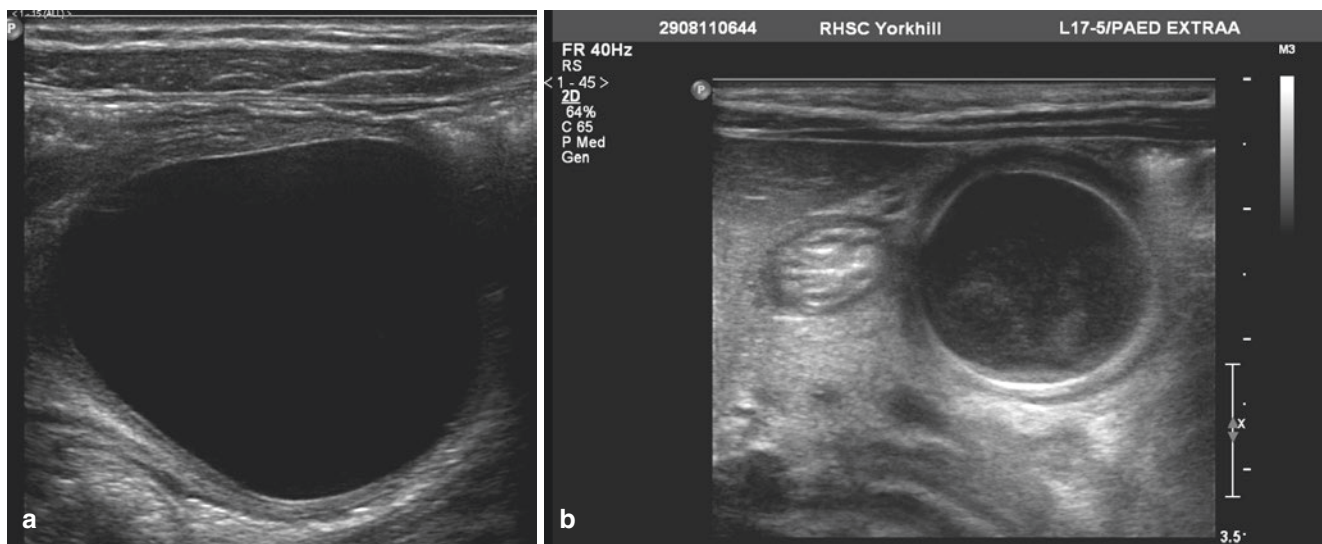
(a) Ultrasound showing duplication of bowel. (b) Ultrasound showing gastric duplication
